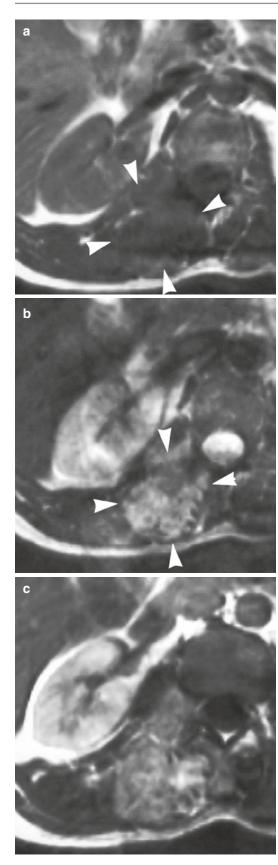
Epithelioid sarcoma in the lumbar paraspinal region in a 37-year-old man. (a) Axial spin-echo T1-weighted MR image. (b) Axial spin-echo T2-weighted MR image. (c) Axial spin-echo T1-weighted MR image after gadolinium contrast injection. On the T1-weighted image, the tumor in the right paraspinal region appears nearly isointense with adjacent muscle and is only visible because of a moderate mass effect that causes asymmetry and distortion of the intermuscular fat planes (*arrowheads*) (a). On the T2-weighted image, the signal intensity of the nodular components within the irregularly outlined lesion is high but intermediate between that of the muscle and subcutaneous fat (*arrowheads*) (b). After contrast medium injection, strong but inhomogeneous enhancement is observed within the tumor (c)
